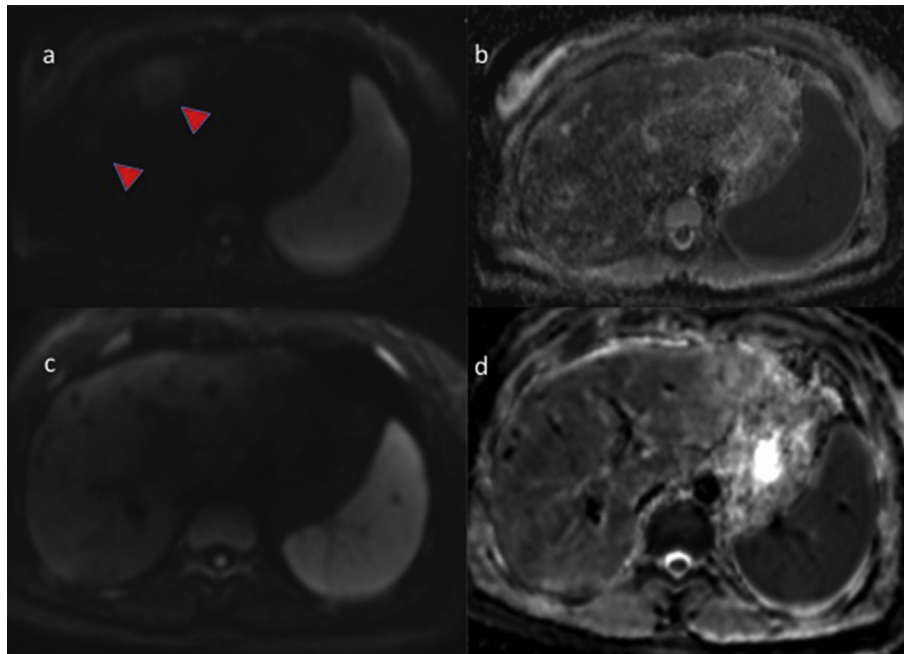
Liver MRI (A–D). Comparison of DWI images (b-value: 800 s/mm²) and corresponding ADC maps at hospital admission (A–B) and after 18 months (C–D).
